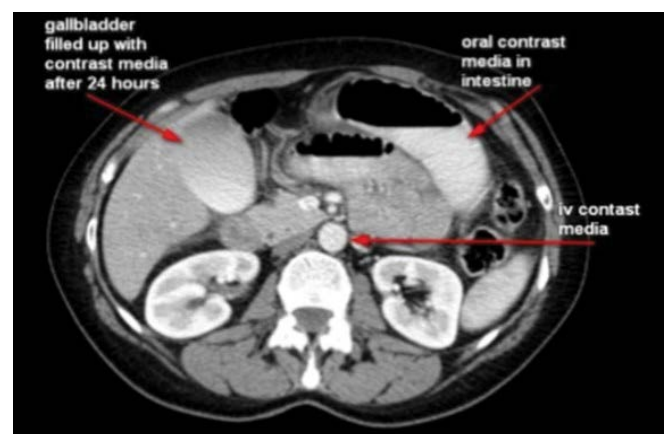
Gallbladder contrast CT, day 1.
